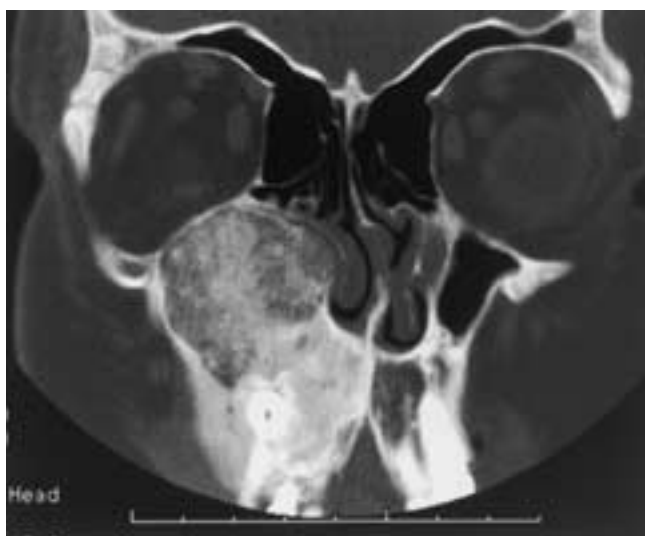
Maxillary monostotic fibrous dysplasia. Coronal CT scan at a bone window setting reveals enlargement of the right maxillary alveolus and hard palate with distortion of dentition. The right maxilla is almost double the size of the left. A very large intrasinus component is present, the appearance of which differs from that in the alveolar bone.
